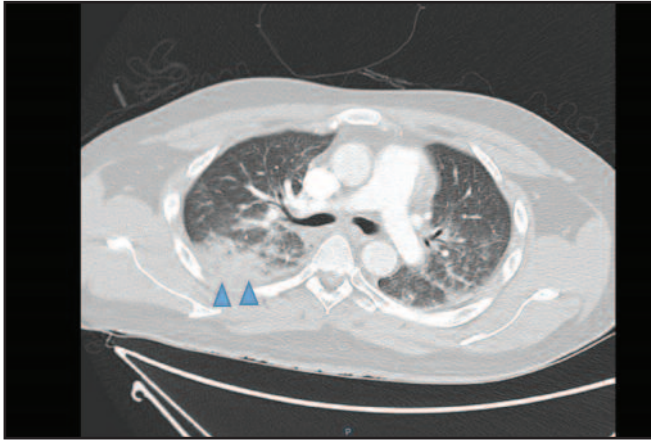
Computed Tomography of the chest showing increased interlobar septal thickening, air space opacities and consolidation predominantly affecting the upper lobes (see arrowheads).
